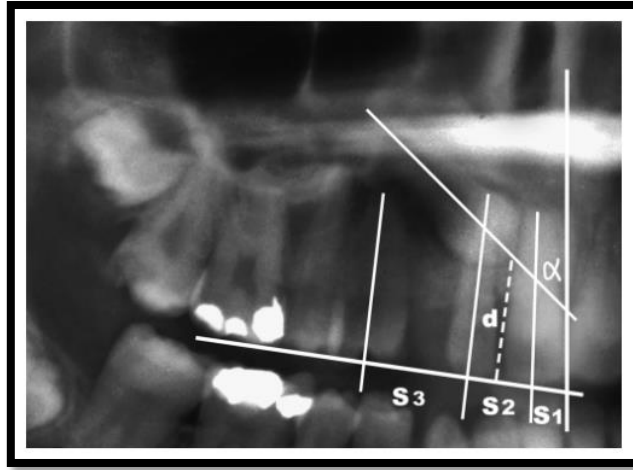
Modified radiographic predictors
